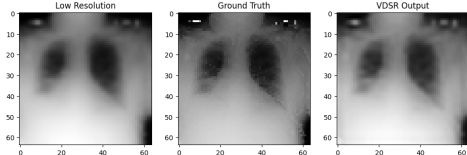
NIH chest X-ray dataset result with VDSR enhancement.
